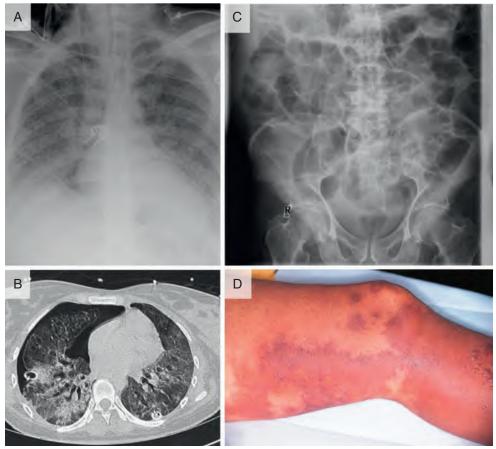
Common complications of sepsis. The most common sepsis complications include brain dysfunction, acute lung injury, acute kidney injury, ileus, cardiovascular dysfunction (including shock), disseminated intravascular coagulation (with thrombocytopenia), and liver injury. (A) Typical chest x-ray and (B) computed tomography scan of acute respiratory distress syndrome showing patchy opacification, loculated pneumothoraces, and bilateral chest drains. (C) Plain abdominal x-ray showing an ileus (note dilated loops of small and large bowel with no cutoff). (D) Purpura as a manifestation of severe disseminated intravascular coagulation. (A from Khan A, Kantrow S, Taylor DE. Acute respiratory distress syndrome. Hosp Med Clin. 2015;4:500–512; B from Randhawa R, Bellingan G. Acute lung injury. Anaesth Intensive Care Med. 2007;8:477–480; C from Glancy DG. Intestinal obstruction. Surgery. 2014;32:204–211; D from Piette WW. Purpura. In: Callen JP, Jorizzo JL, Zone JJ, Piette W, Rosenbach MA, Vleugels RA, eds. Dermatological Signs of Systemic Disease. 5th ed. Philadelphia: Elsevier; 2017:109–116, courtesy Dr. Neil A. Fenske, Tampa, FL.)
